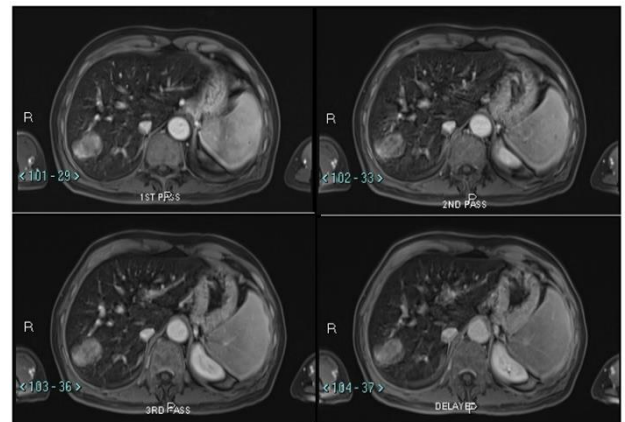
Magnetic resonance imaging of the liver that shows lobulated mass in segment VII, with mild heterogeneous contrast enhancement without significant enhancement in the arterial phase or washout or pseudo capsule on portal venous or delayed phases.
